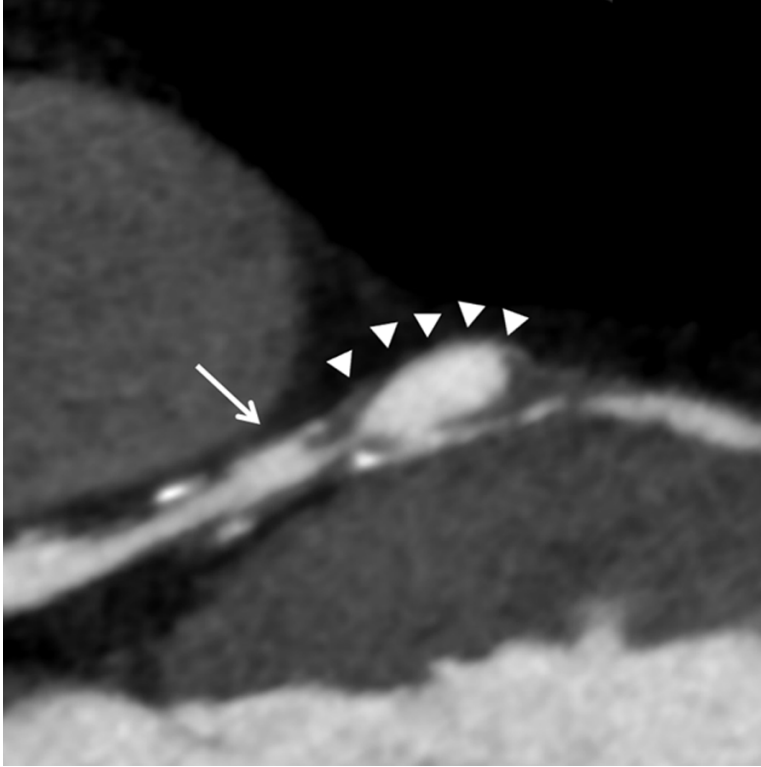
Computed tomography coronary angiography (curved multiplanar reconstruction) revealed a giant proximal left anterior descending coronary artery aneurysm (arrow-heads). The aneurysm measured 13×6 mm, and we observed an intra-plaque cavity with a ruptured fibrous cap (arrow) adjacent to it.
